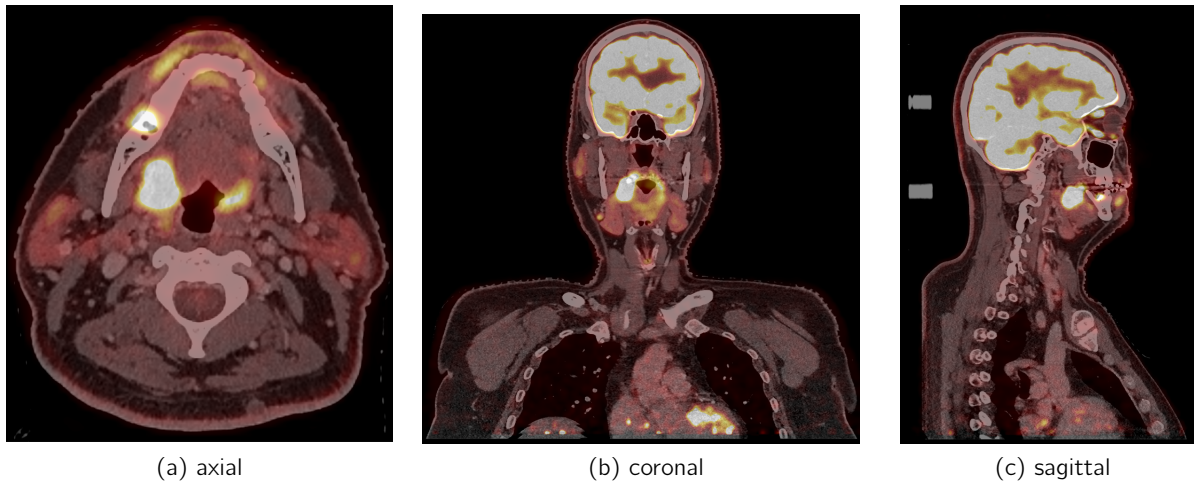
The tumour in the right tonsil loge in three different views on FDG PET with a diagnostic CT
